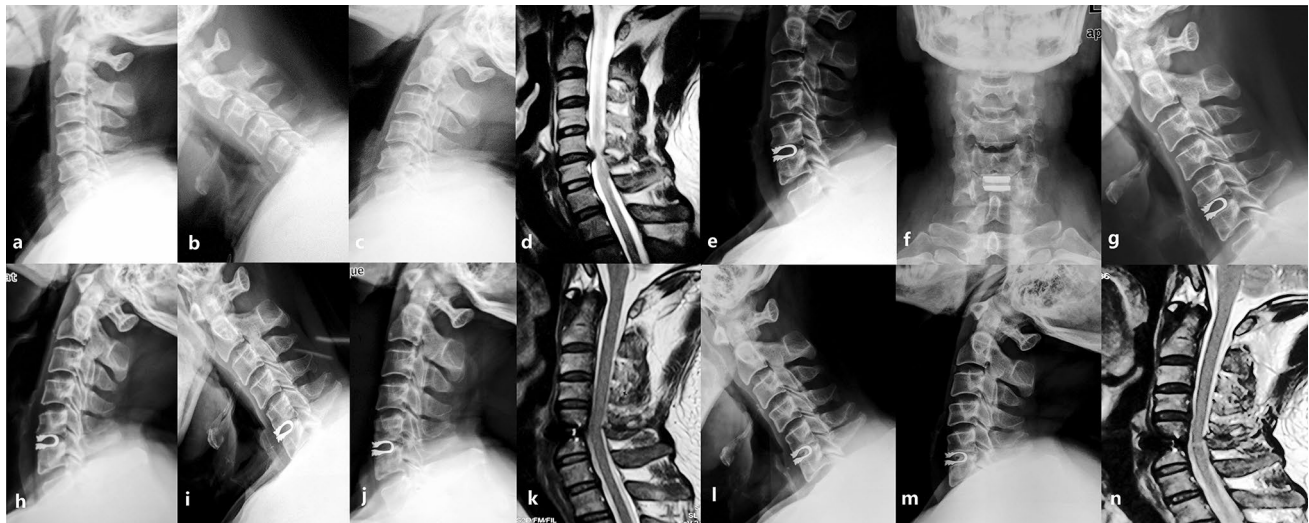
A 47-year-old man presented with progressive numbness in her two hands and weakness in his four extremities for 2 years. a Preoperative lateral view X-ray. b, c Preoperative ROM of C4–C5, C5–C6 and C6–C7 was 7.9°, 7.3° and 7.5° on flexion-extension lateral view X-ray. d Preoperative T2-weighted midsagittal MRI images showed disc herniation in C5–C6, Miyazaki grade of C4–C5 was grade II, and C6–C7 was grade. e, f Lateral and posterior-anterior view X-ray at postoperative 3 months showed DCI was in good position. g, h The ROM of C4–C5, C5–C6 and C6–C7 was 8.0°, 7.5° and 7.9° on flexion-extension lateral view X-ray at postoperative 3
